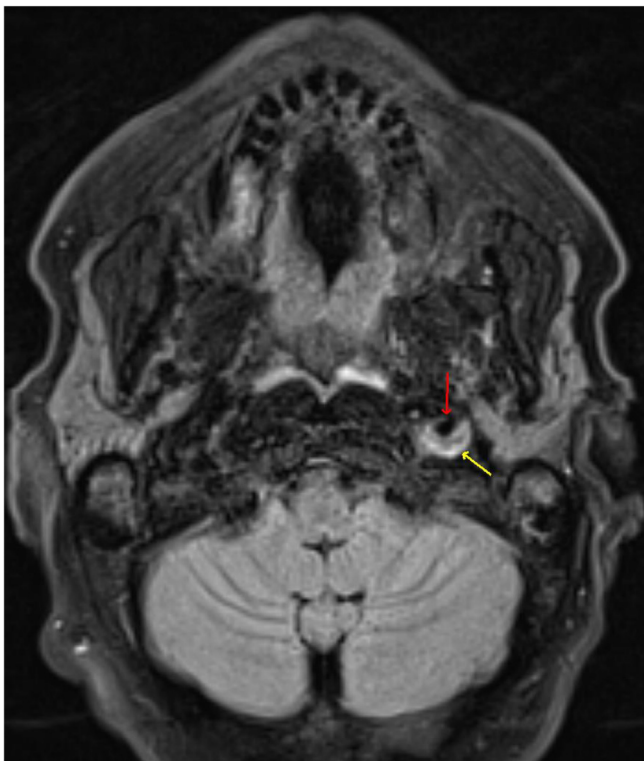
Head MRI at presentation: Axial fat-saturated FLAIR (Fluid-Attenuated Inversion-Recovery) image at the level of the skull base demonstrate intramural blood products consistent with arterial dissection (yellow arrow) along the posterior aspect of the left ICA (red arrow), corresponding to the abnormal soft tissue density on the CTA source images.
